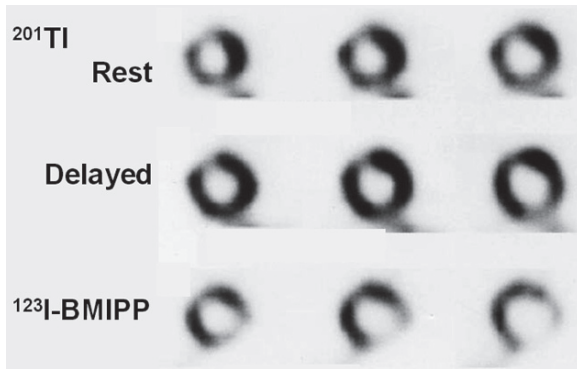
PET and SPECT radiotracers of free fatty acid analogs to assess myocardial metabolism
